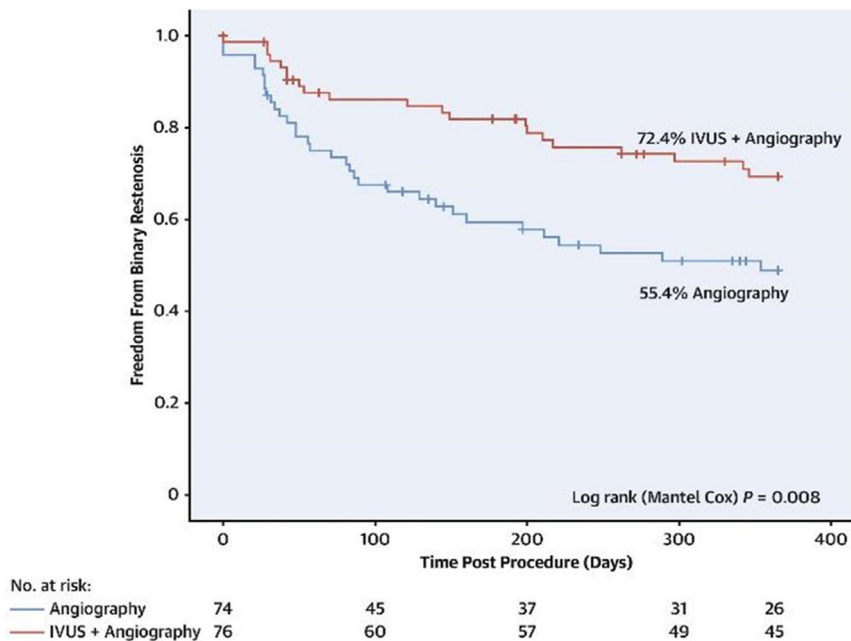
Kaplan–Meier curve of 12-month freedom from binary restenosis after femoropopliteal endovascular intervention using angiography (blue) and intravascular ultrasound (IVUS) + angiography (red) in a single-center randomized trial. Reprinted with permission from Allan et al, 2022.²⁹
